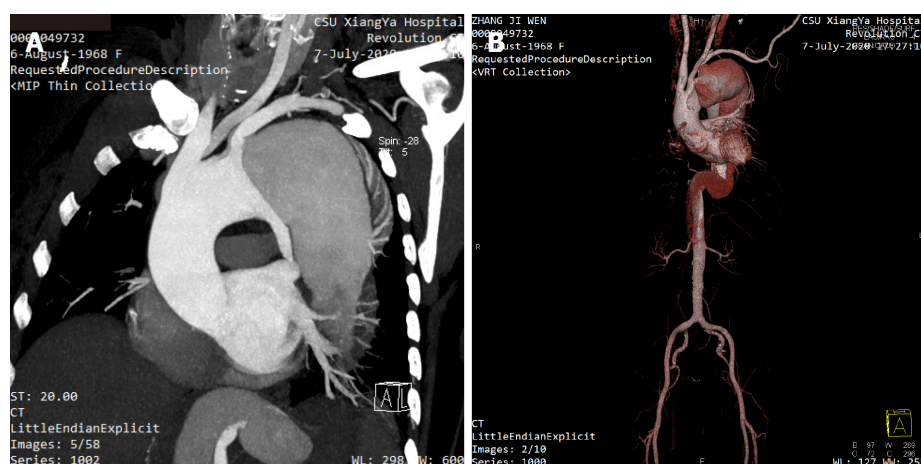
Contrast-enhanced computed tomography angiography of the aorta. A: Coronal plane showing an aortic dissection of the aortic arch with a sizeable false lumen; B: 3D reconstruction image of the full-length aorta.
